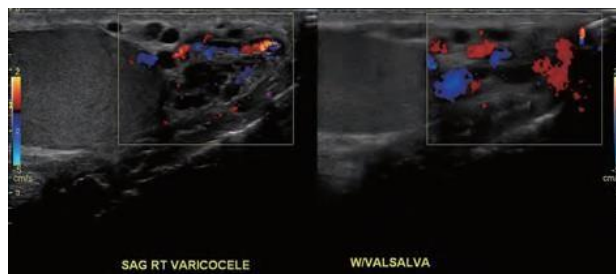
Grade 3 right-sided varicocele ultrasound image. [99].
